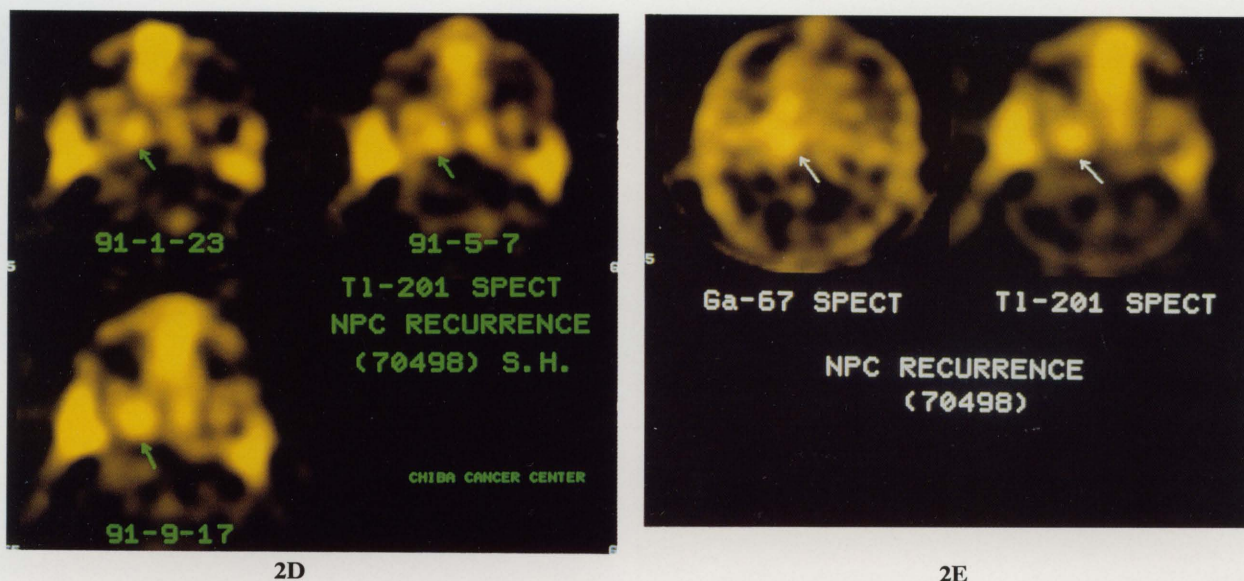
A-E. Case 9 in Table 1, A 67-year-old male with NPC. A. Tl-weighted MR image showing a low intensity lesion of the right parapharyngeal space. B. Tl-weighted MR image after the administration of Gd-DTPA shows diffuse enhancement of the lesion. C. Tl-201 SPECT positively delineates the lesion at right parapharyngeal space. D. Tl-201 SPECTs serially taken in January, May, and September, 1991. A small increased uptake by the right parapharyngeal lesion is already shown in January, 1991 (arrow). E. Comparison between Ga-67 and Tl-201 SPECT images. The lesion detected by Tl-201 SPECT well corresponds to the lesion enhanced on MR image than Ga-67 SPECT.
